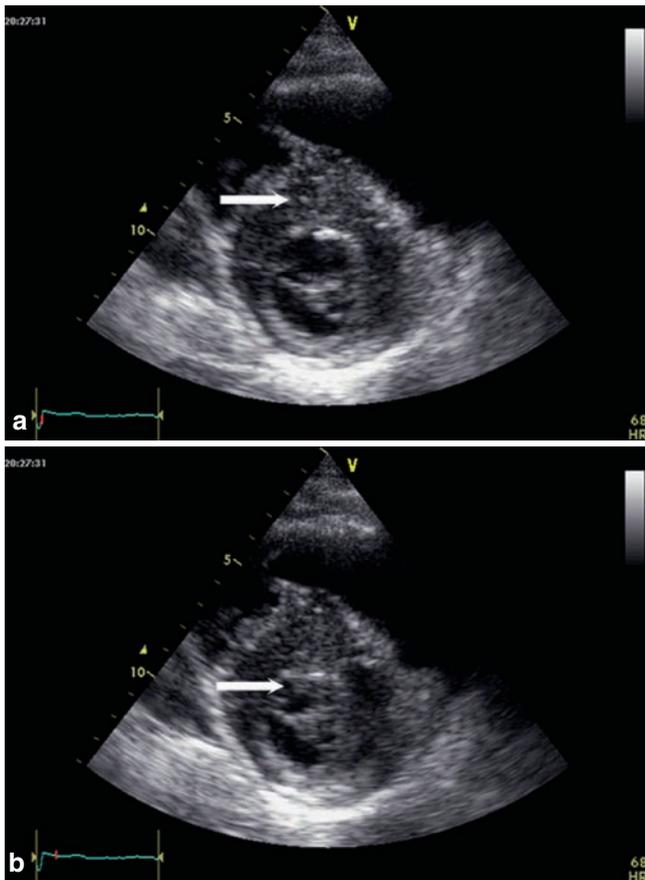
Basal parasternal short-axis view of hypertrophic obstructive cardiomyopathy. Note “asymmetrically” thickened septum (end-diastole) (arrow in (a)). In early systole, the anterior leaflet is seen to obstruct the outflow tract (arrow in (b))
